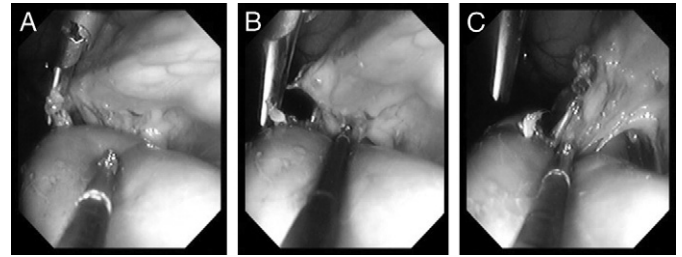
Gastroscopic image reveals renal artery ultrasonic ligation. A, starting ligation. B, finishing ligation. C, completed ligation.
